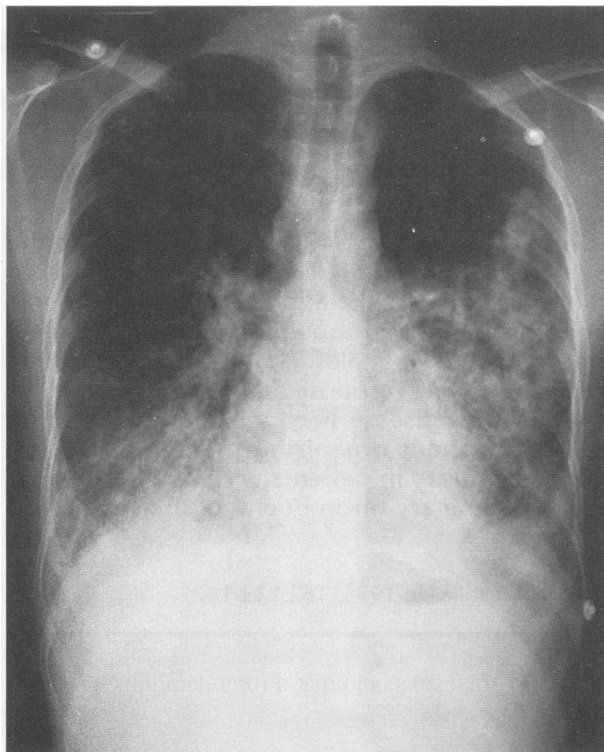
The admission chest radiograph of the young man with fulminant *Mycoplasma pneumoniae* pneumonia shows diffuse alveolar infiltrates, particularly in the lower lung fields.
